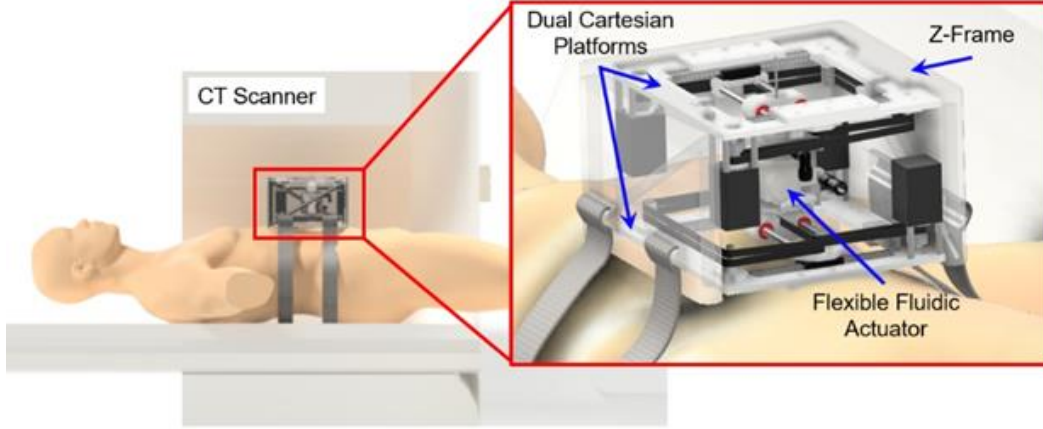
CAD model of the liver ablation robot mounted on the patient within CT scanner.
